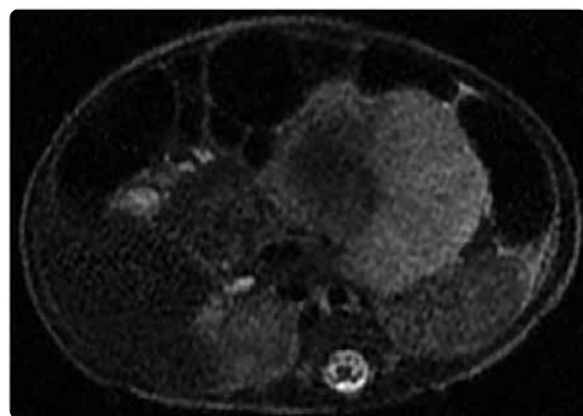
Abdominal MRI sequence with T2 axial information: oval mass located in the mesentery, well defined, predominantly high signal with areas of low signal due to probable necrosis.
